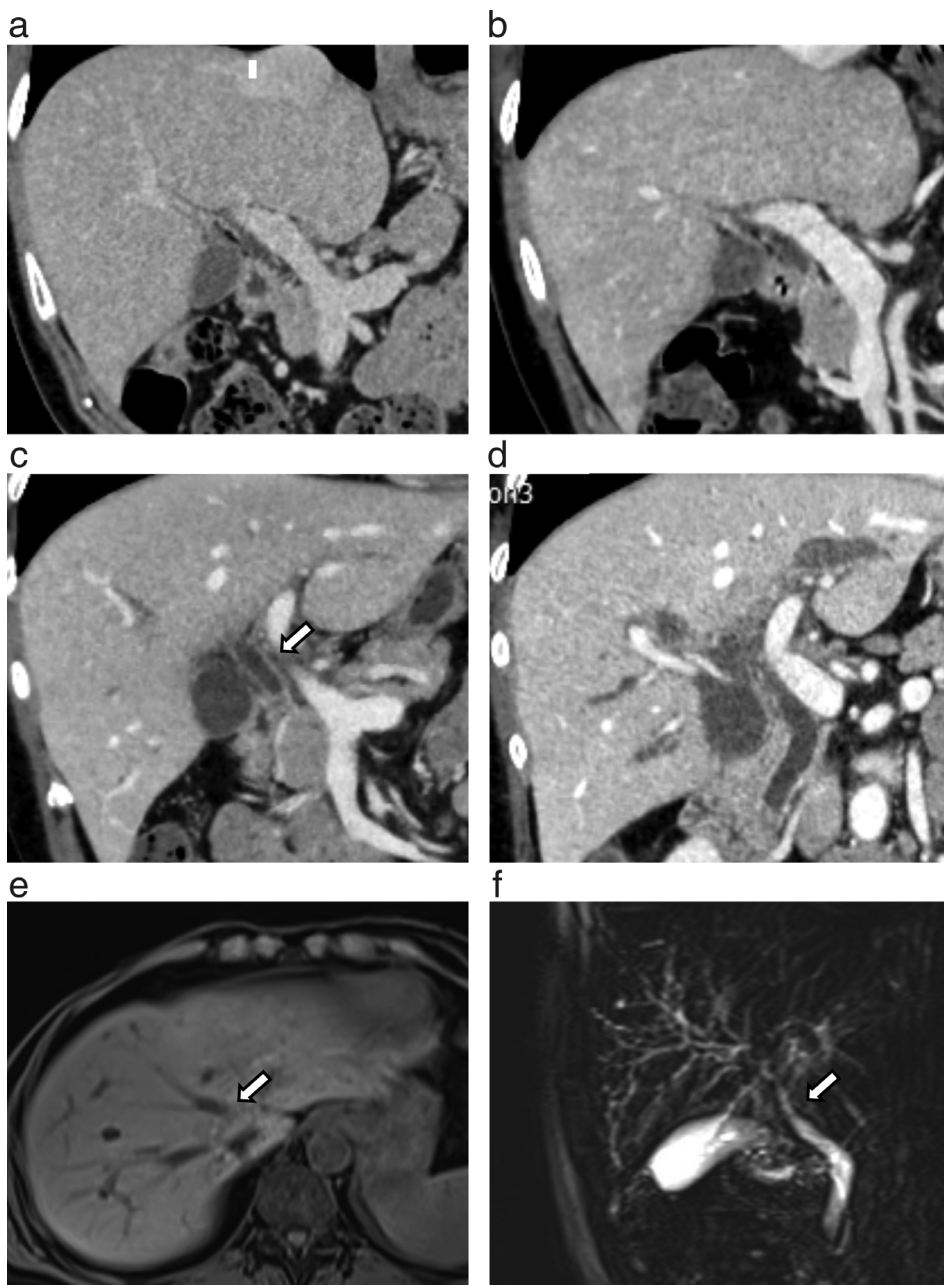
Imaging of the patient. Contrast-enhanced computed tomography scan (a) before neoadjuvant chemotherapy in August 2015, (b) during the eight cycles of weekly nab-paclitaxel and trastuzumab for metastasis, (c) on hospital day 5 and (d) after the termination of lapatinib and vinorelbine. (e) Upper abdominal magnetic resonance imaging and (f) magnetic resonance cholangiopancreatography on day 15
